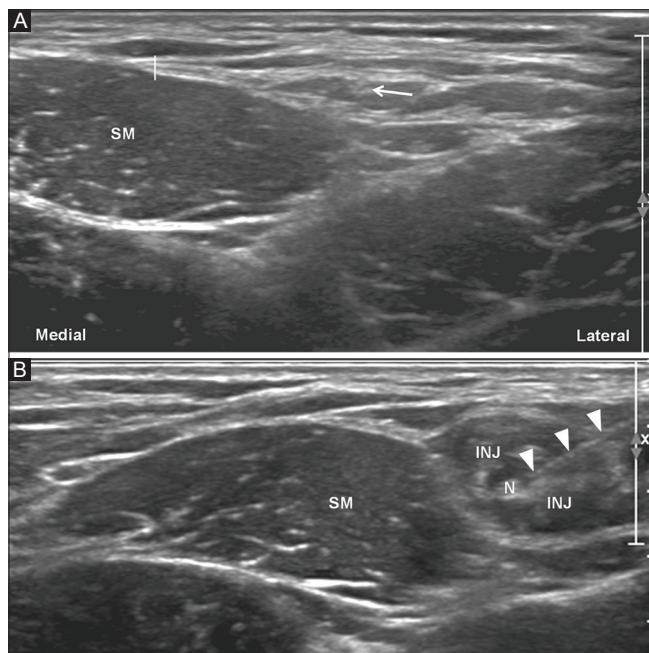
(A and B): (A) Ultrasound transverse image with the probe kept approximately 4–5 cm below the anterior superior iliac spine in the lateral part of the upper thigh showing the sartorius muscle (SM) and the lateral cutaneous nerve of thigh (white arrow) lateral to the muscle. (B) Ultrasound image showing a needle (white arrowheads) placed with its tip close to the lateral cutaneous nerve of thigh (N) and injectate (INJ) spread around the nerve. Sartorius muscle is shown (SM)
